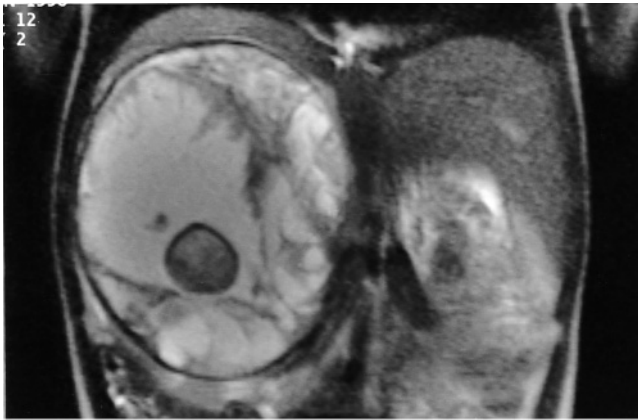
Wilms tumor. T1-weighted precontrast fat-suppressed SE (a), T2-weighted ETSE (b), and T1-weighted interstitial-phase fat-suppressed gadolinium-enhanced SE (c) images. A large mass arises from the right kidney and demonstrates central linear
